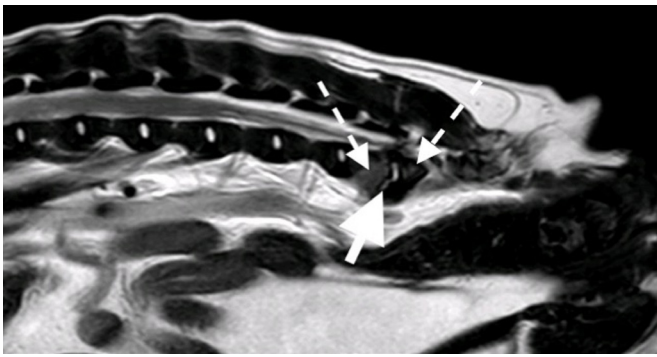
Sagittal T2-weighted MRI of the lumbosacral spinal cord of case 1 demonstrating the irregular hyperintense L7–S1 intervertebral disc (large white arrow) and hyperintensity of the vertebral endplates (dashed white arrows).
